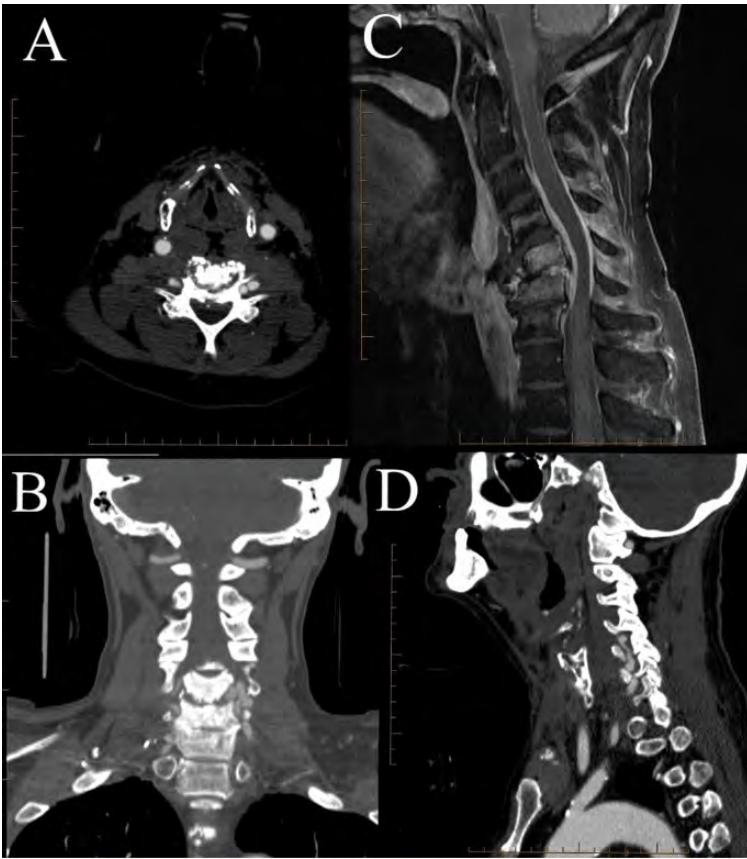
(A) CT Neck Angiography – Axial view at C5-C6 level (B) CT Neck Angiography – Coronal view (C) Sagittal T1 post contrast (D) CT Neck Angiography – Sagittal view demonstrating pseudoaneurysms of the left vertebral vessels
